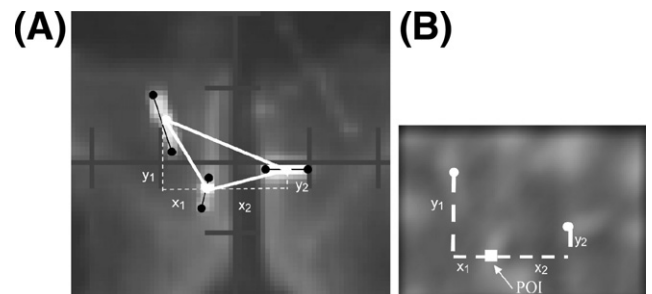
(A) Inter-marker distances in terms of their x- and y-components (x_1 , x_2 , y_1 and y_2) are found by measuring the distance in pixels between the center of each marker in the digitally reconstructed radiographs. (B) A contrast image showing a point of interest (POI) and the 2 POIs associated with it found using the inter-marker distances.
